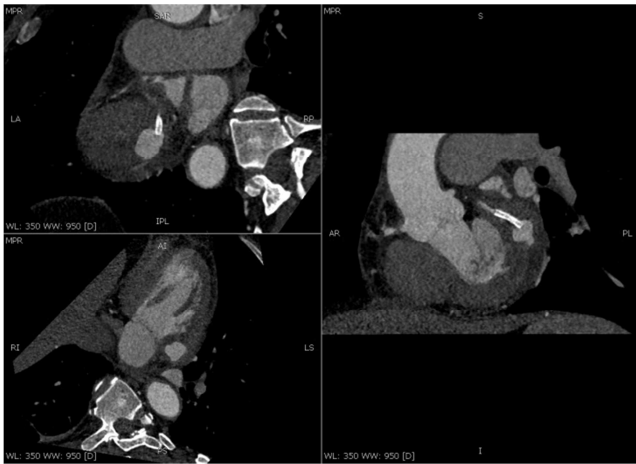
Multiplanar views of coronary CT angiogram showing stent in LCX with a distal PSA.
